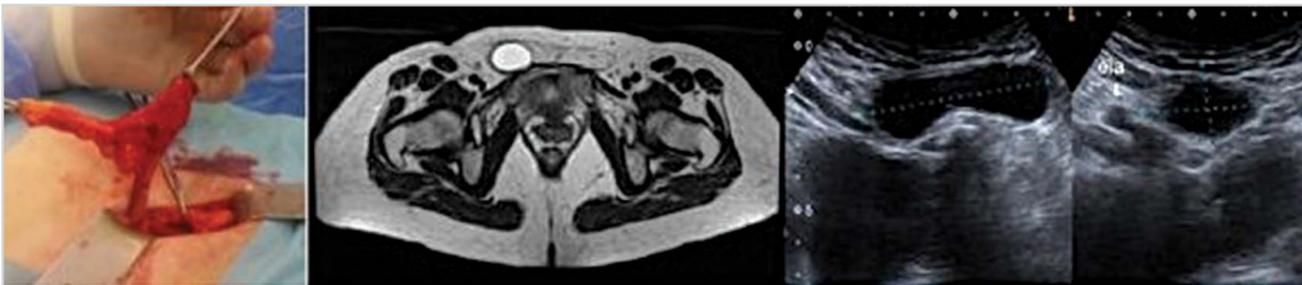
Intraoperative findings, MRI findings and US findings of second case.
